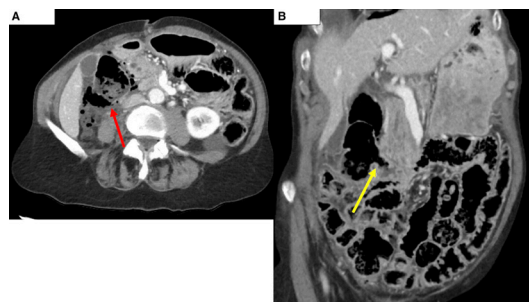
(A) Red arrow designating defect in DD seen on axial CT series. (B) Yellow arrow identifying the neck of the DD on coronal CT series. DD, duodenal diverticulum.
